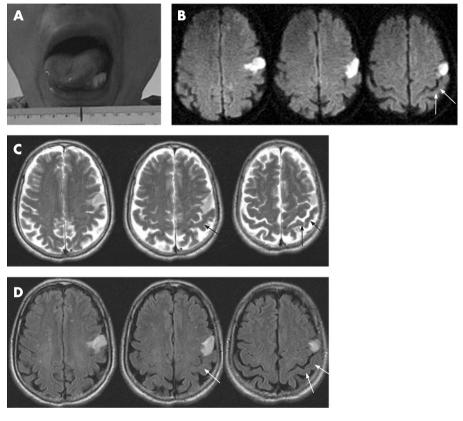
(A) The protruded tongue deviating to the right about 1.5 cm from the midline. (B) Diffusion weighted, (C) T2 weighted image and (D) fluid attenuated inversion recovery (FLAIR) magnetic resolution images of the brain showed a small cortical infarction in the precentral gyrus of the left frontal lobe. White and black arrows indicate the precentral knob representing the motor hand area.
